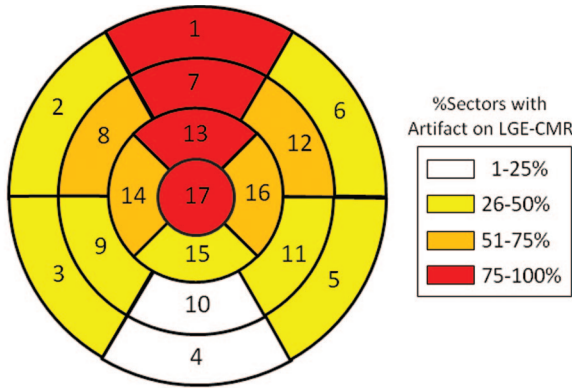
Artifact effects on late gadolinium-enhanced cardiac magnetic resonance imaging (LGE-CMR). Artifact effects in each plane of LGE-CMR caused by the generator were quantitatively assessed in patients with left- and right-sided implantable cardioverter-defibrillator (ICD)/biventricular (BiV)-ICD or pacemaker (PM) systems. A, The greatest artifact on LGE-CMR was observed in patients with left-sided ICD/BiV-ICD. About 50% of the sectors were affected by the artifact. B, Details about the regional artifact effects on short-axis (SA) planes are demonstrated in patients with left-sided ICD/BiV-ICD and PM systems. The anterior and apical regions were severely affected by artifacts caused by the generator in patients with ICD/BiV-ICD systems. Smaller artifacts were observed in patients with left-sided PM systems. C, The regional artifact effects on HLA and VLA plane are shown in patients with left-sided ICD/BiV-ICD systems. The apical regions on HLA and VLA planes were severely affected by the artifact.
